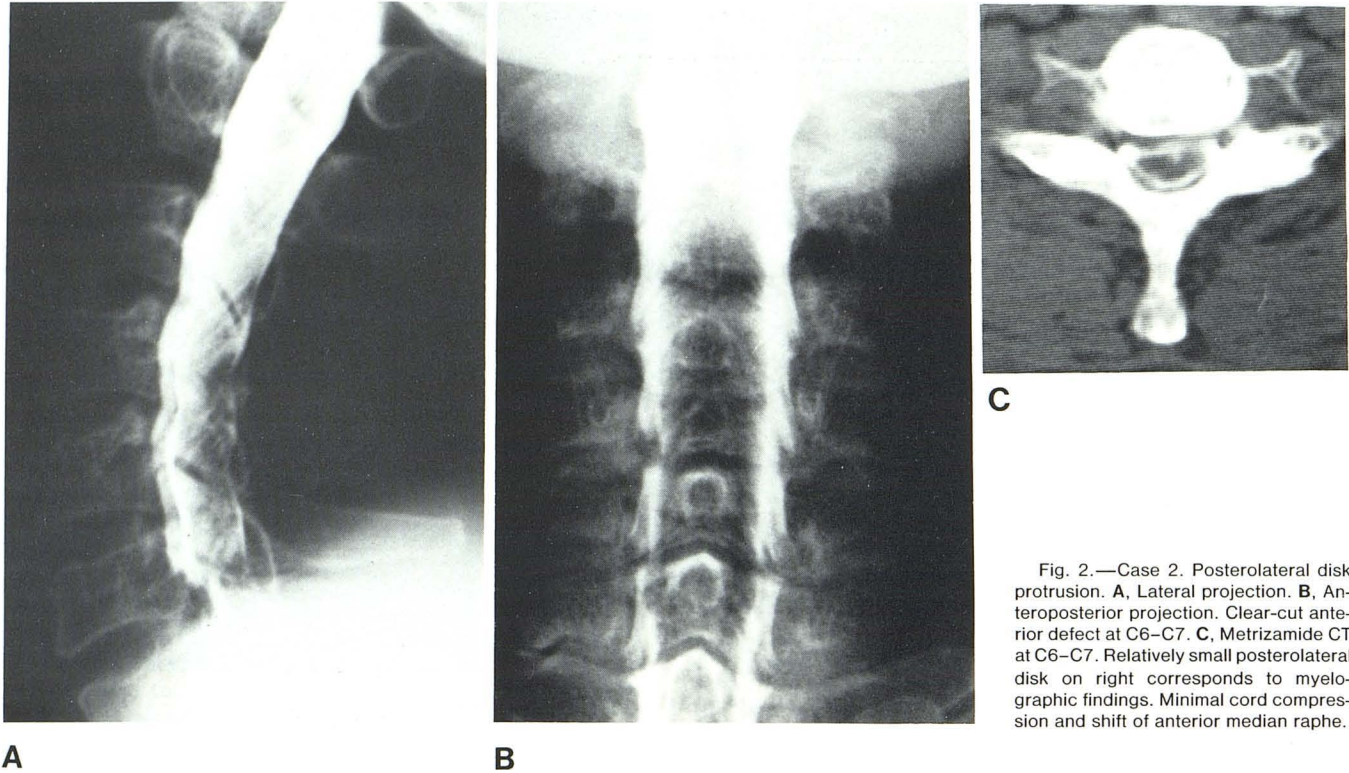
Case 2. Posterolateral disk protrusion. A, Lateral projection. B, Anteroposterior projection. Clear-cut anterior defect at C6–C7. C, Metrizamide CT at C6–C7. Relatively small posterolateral disk on right corresponds to myelographic findings. Minimal cord compression and shift of anterior median raphe.
